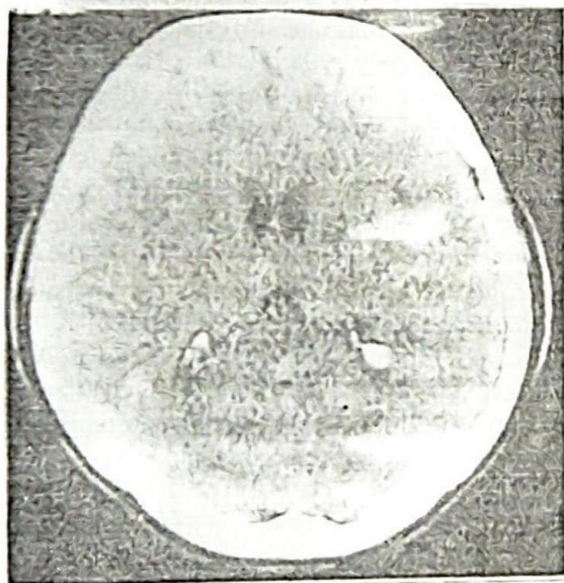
Normal CT brain scan for comparison
